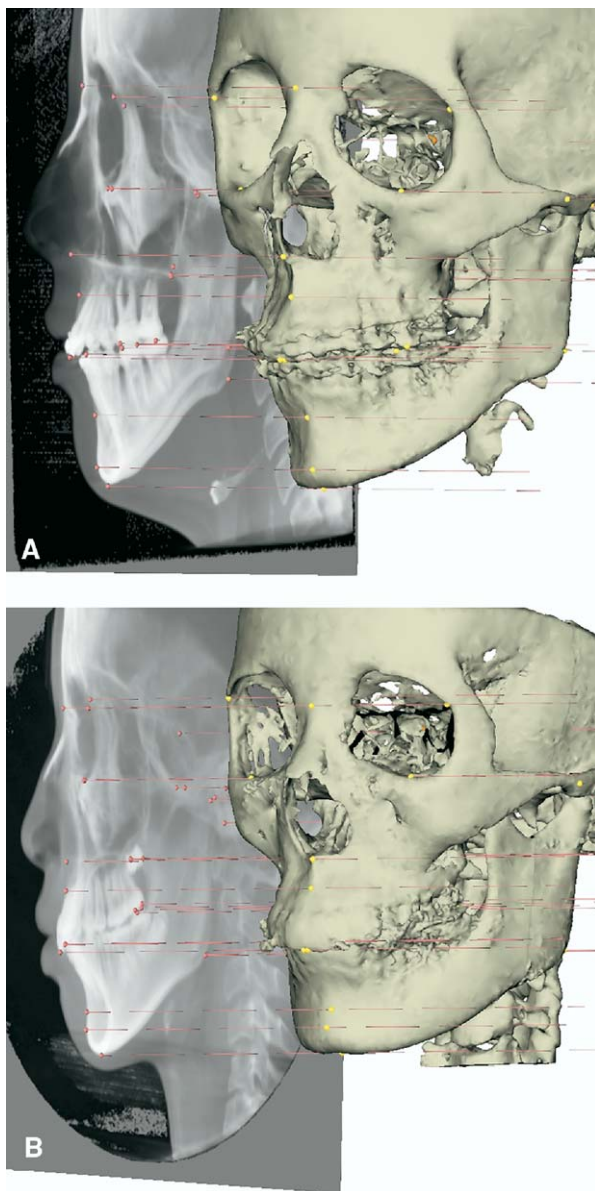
Virtual lateral cephalograms linked to 3D hard-tissue surface representations with setup of 3D cephalometric hard-tissue landmarks: A, i-CAT and B, Hitachi CBCT.
